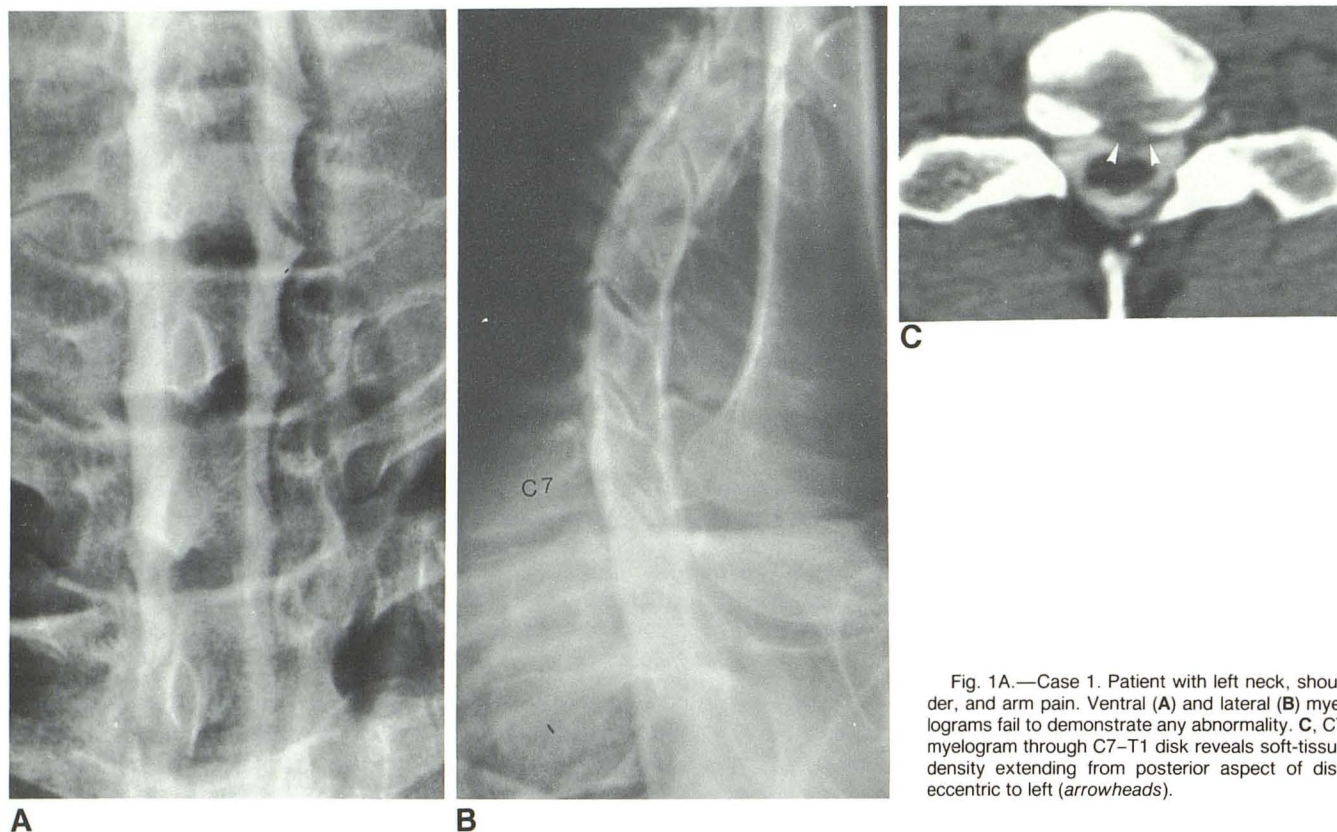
Case 1. Patient with left neck, shoulder, and arm pain. Ventral (A) and lateral (B) myelograms fail to demonstrate any abnormality. C, CT myelogram through C7–T1 disk reveals soft-tissue density extending from posterior aspect of disk eccentric to left (arrowheads).
